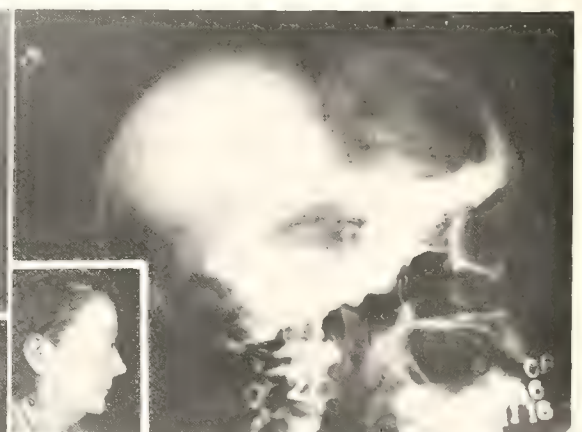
Meningioma of the sphenoid ridge extending into the posterior orbital wall. The roentgenogram shows marked condensation of bone.
